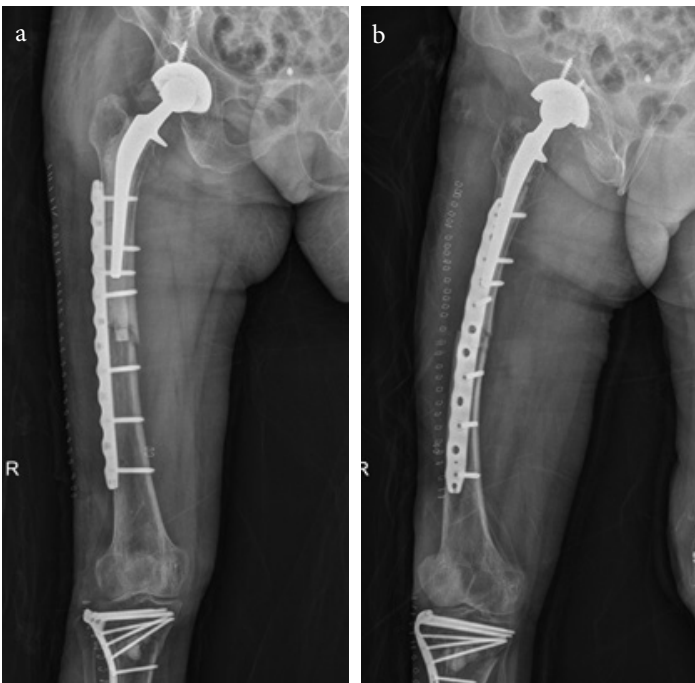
a, b. Postoperative AP (a) and oblique radiograph showing appropriate reduction and fixation (b)
